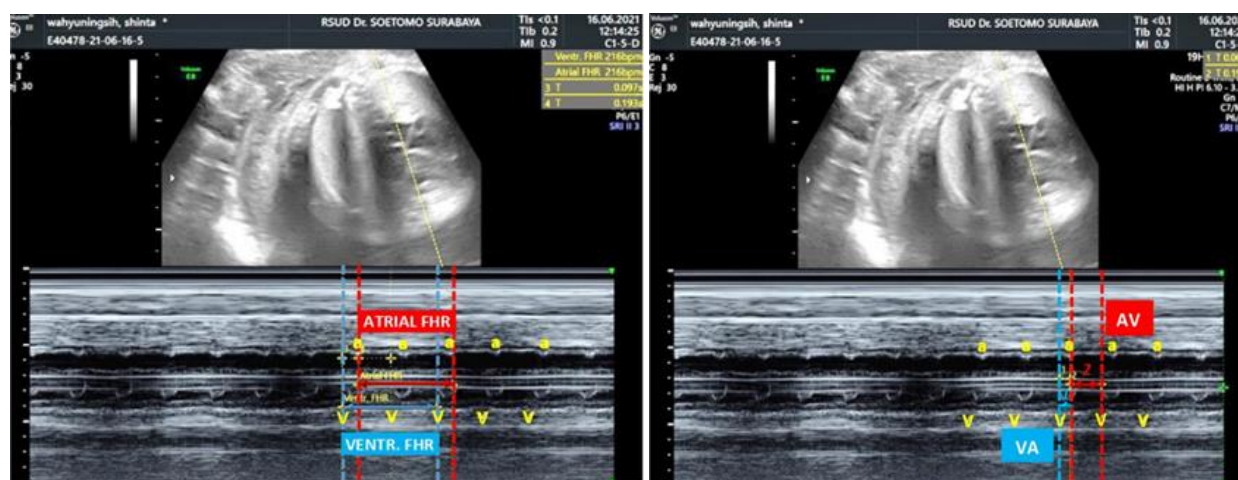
Results of the M-mode echocardiogram (Date: June 16, 2021). It showed each atrial and ventricular heart rates of 216 bpm during all examinations and regular. The relationship of atrial and ventricular contractions was 1:1, with a short VA interval (VA:AV ratio <1) indicating a sustained supraventricular tachyarrhythmia. There was no fetal hydrops or polyhydramnios
